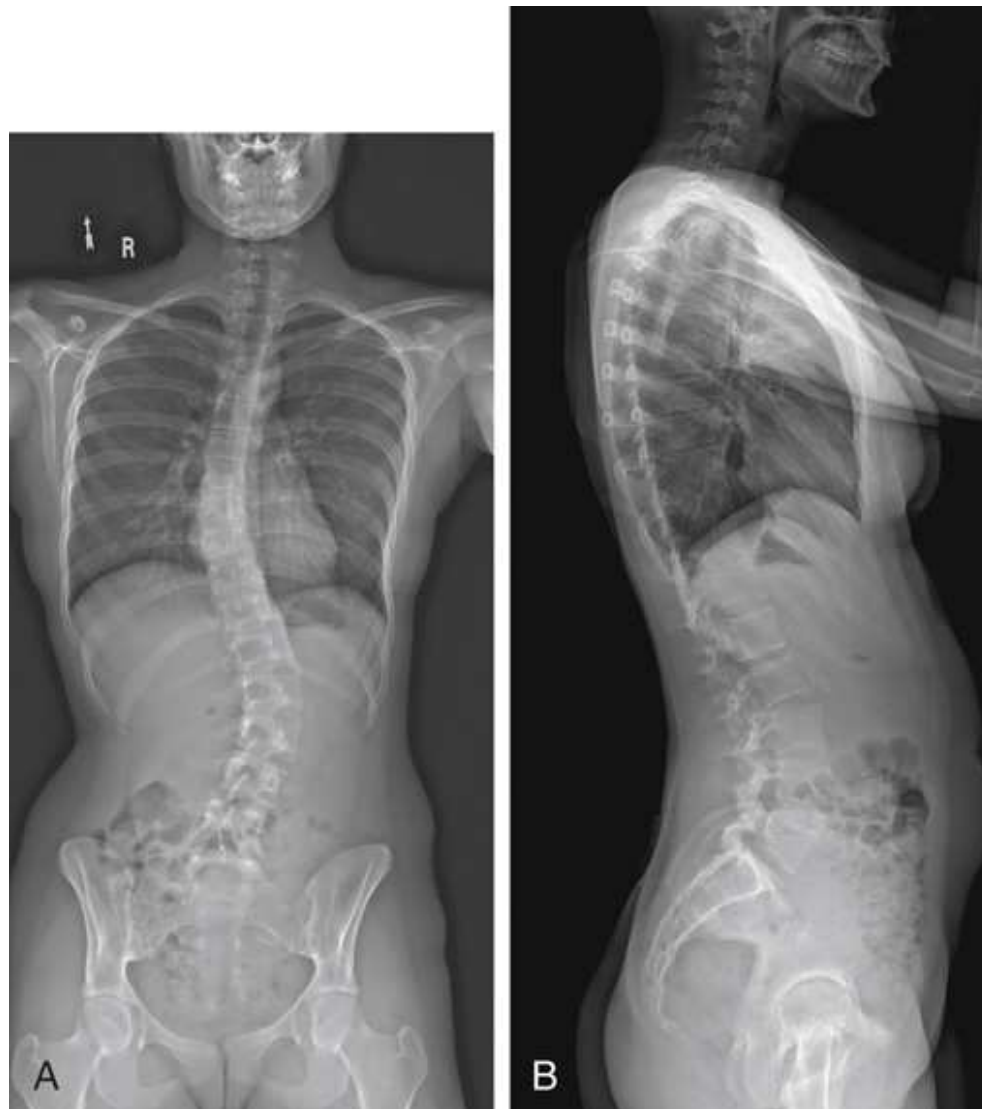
Standing full-spine radiographs acquired by the microdose unit in Fig. 9.135. (A) PA projection. (B) Lateral projection.
